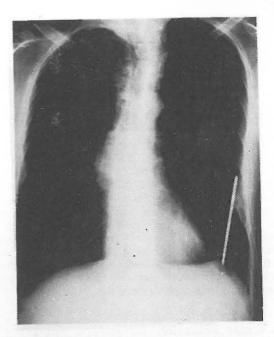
Posteroanterior roentgenogram after removing thewire within the subcutaneous tissue
